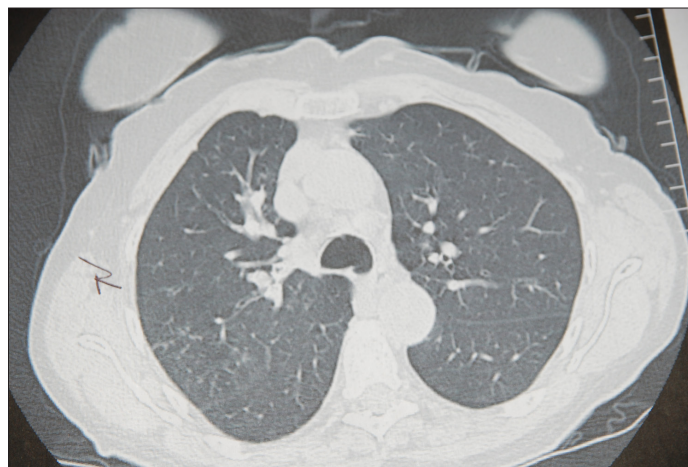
High resolution computed tomography scan of the chest 13 weeks post-onset of chronic cough.
